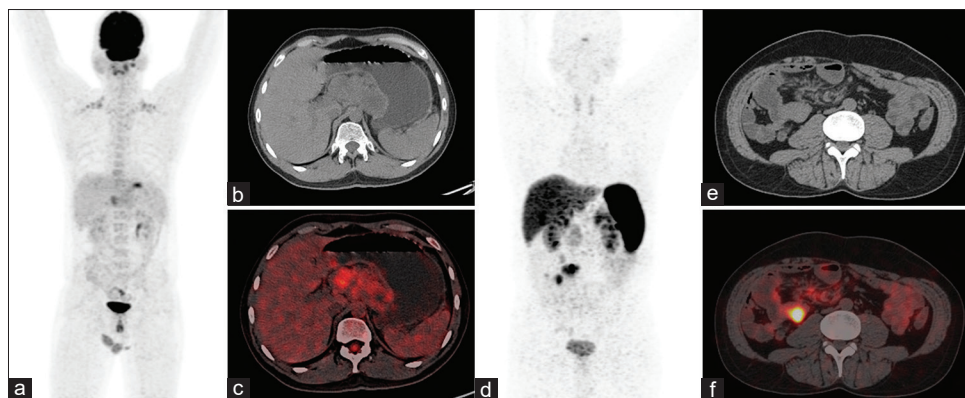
Case of 31-year-old male who diagnosed with Neuro-endocrine tumor (Grade 3) of the Distal stomach and underwent Baseline 18F-FDG positron emission tomography/computed tomography (MIP [a], Axial computed tomography [b], Axial Positron emission tomography/computed tomography [c]); which revealed a metabolically active mass involving the distal stomach and no other site of involvement. Also shown is the 68Ga-DOTANOC Positron emission tomography/computed tomography images (MIP [d], Axial computed tomography [e], Axial Positron emission tomography/computed tomography [f]) in a 48-year-old male with Grade 2 ileal carcinoid, showing increased tracer uptake in the primary mass as well as metastatic lymph node. Higher grade Neuro-endocrine tumors do not show adequate differentiation and hence Somatostatin Receptor expression, making 18F-FDG an ideal choice of tracer. On the other hand, low grade Neuro-endocrine tumors do show high expression of Somatostatin Receptor and are better visualized with Somatostatin Receptor imaging
